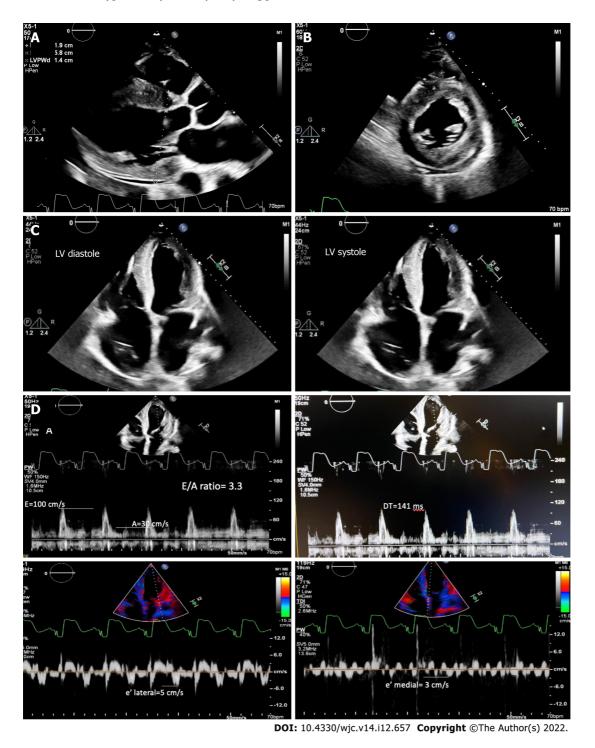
Transthoracic echocardiography. A: Parasternal long axis of left ventricle shows concentric hypertrophy with an increased interventricular septum and posterior wall thickness and a trivial pericardial effusion; B: Parasternal short axis showing thickened walls of the left ventricular myocardium; C: Four-chamber view showing lehigh valley diastole and systole; D: E/A ratio of 3.3, severely reduced mitral annular tissue velocities (e' medial of 3 cm/s and e' lateral of 5 cm/s), E/e' of 25, and deceleration time time of 141 ms, consistent with restrictive pathology. LV: Lehigh valley.
